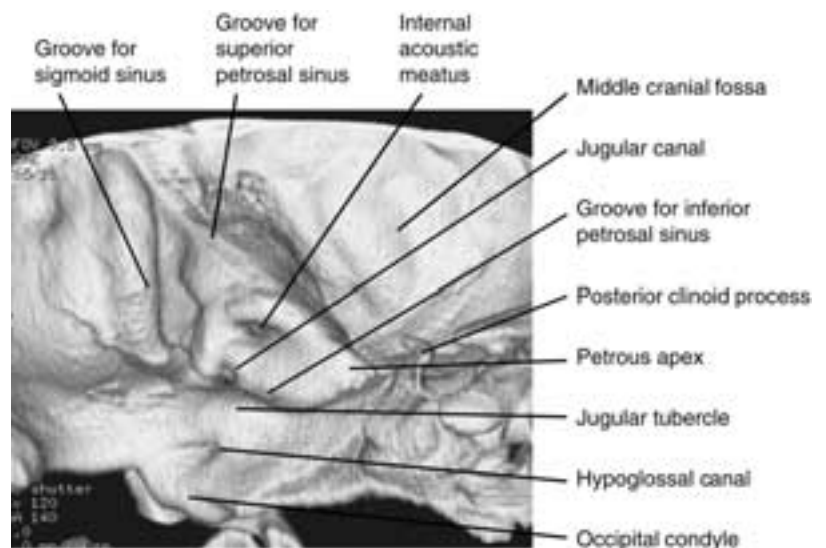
Three-dimensional CT surface reconstruction, from medially and slightly superiorly. This is a view of the medial surface of the temporal bone. The hypoglossal canal is seen interposed between the occipital condyle and the jugular tubercle. The IAC is seen in the midportion of the temporal bone. The vascular grooves for the sigmoid sinus and the superior petrosal sinus are well seen.
